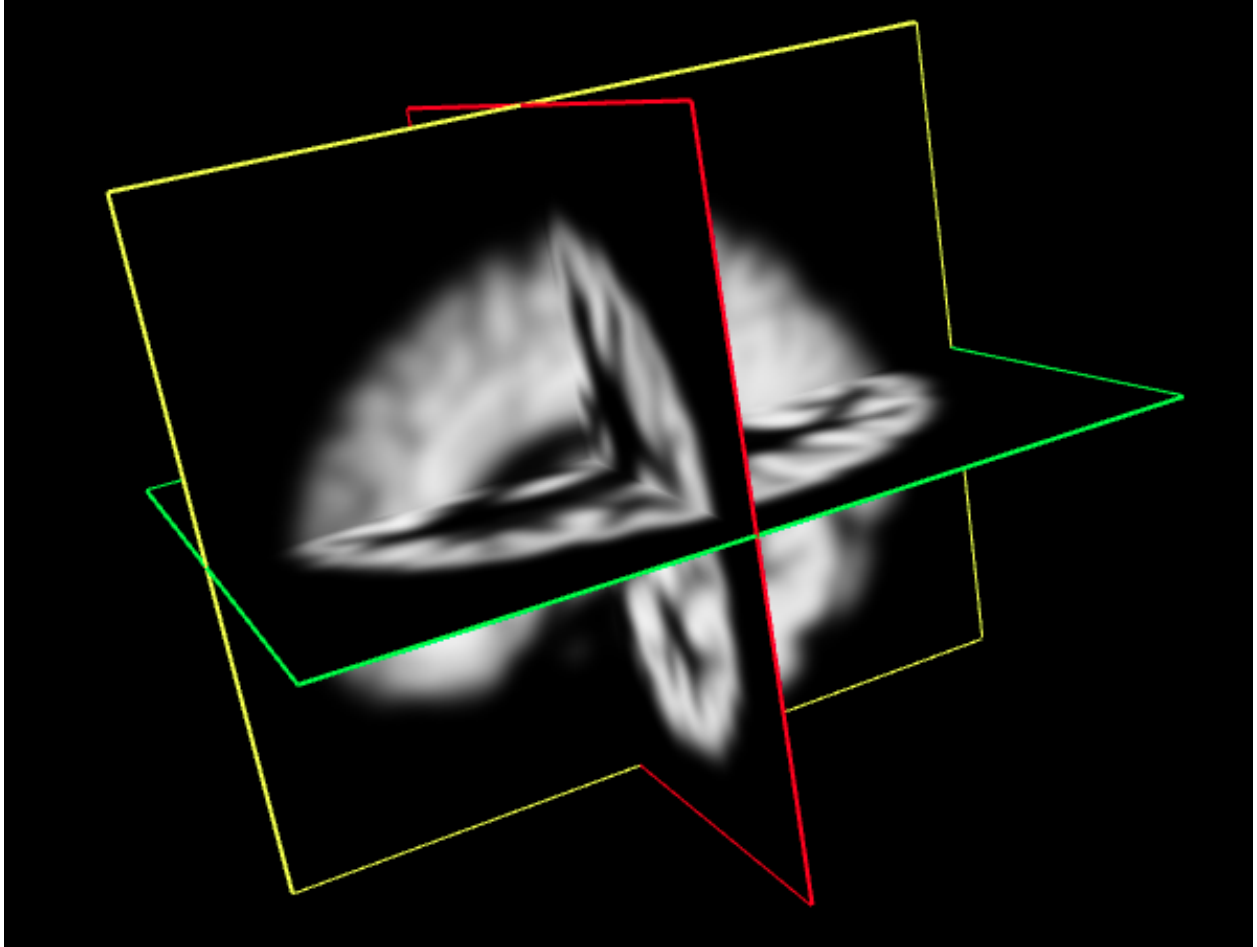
Brain MRI visualization
